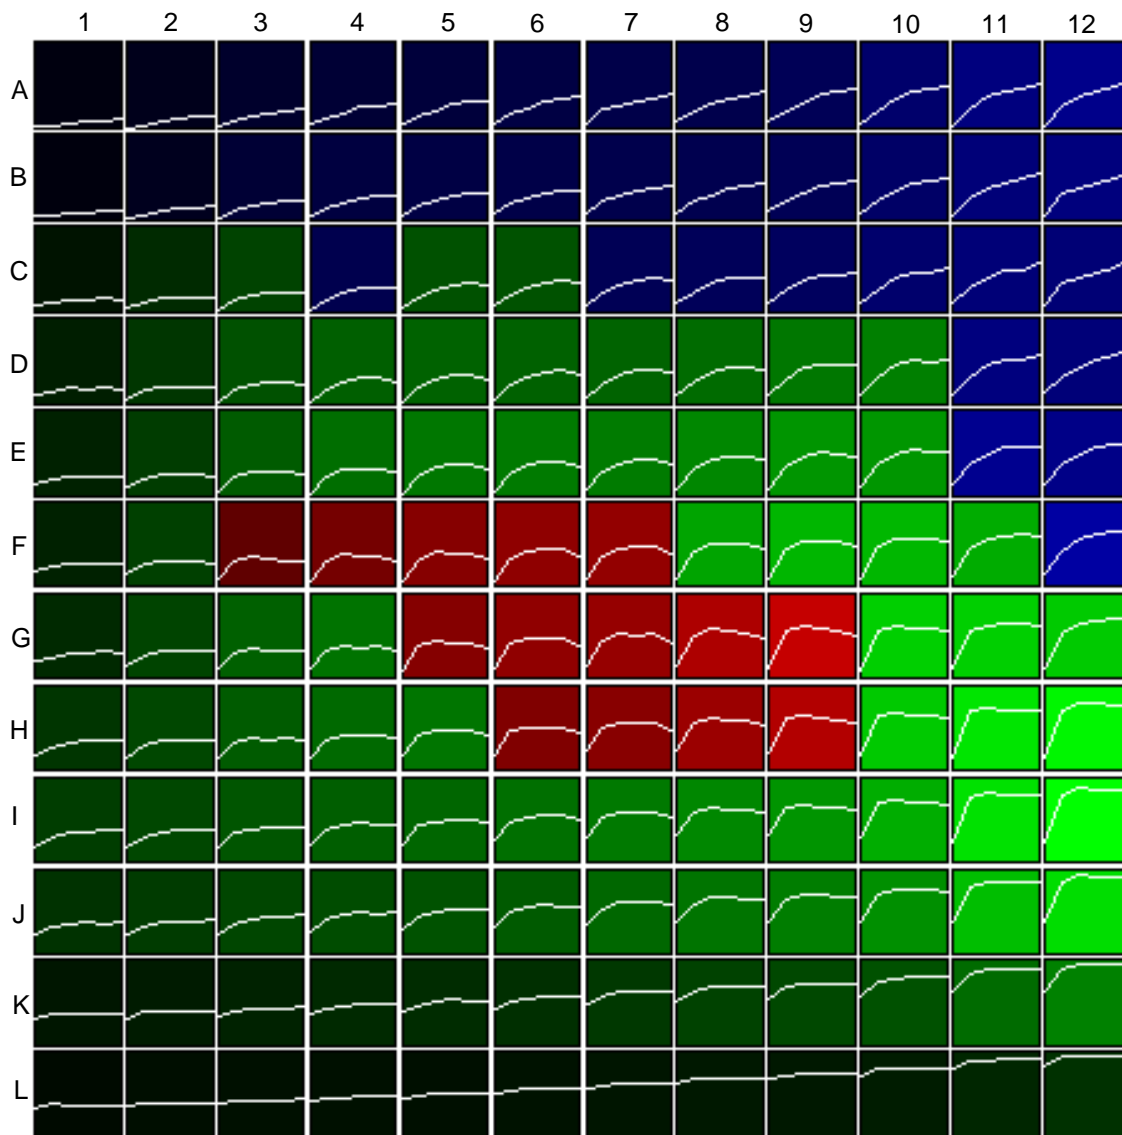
Adaptive colour scale of the DCE-MRI data coloured using the 3TP pixel-mapping. The line plot at position x, y depicts the signal course of the prototype with lattice coordinate x, y and the pseudo-colour computed with 3TP for the corresponding prototype.
